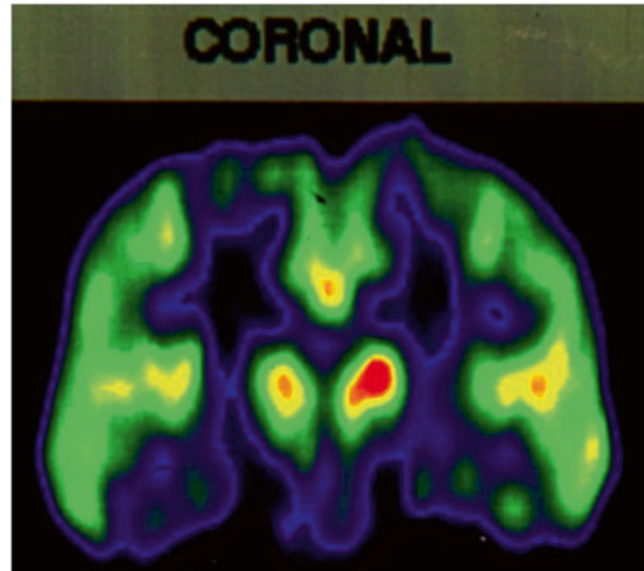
^{18}F -FDG PET findings in a ALS patient with upper motor neuron involvement as well as lower motor neuron clinical findings: coronal view
